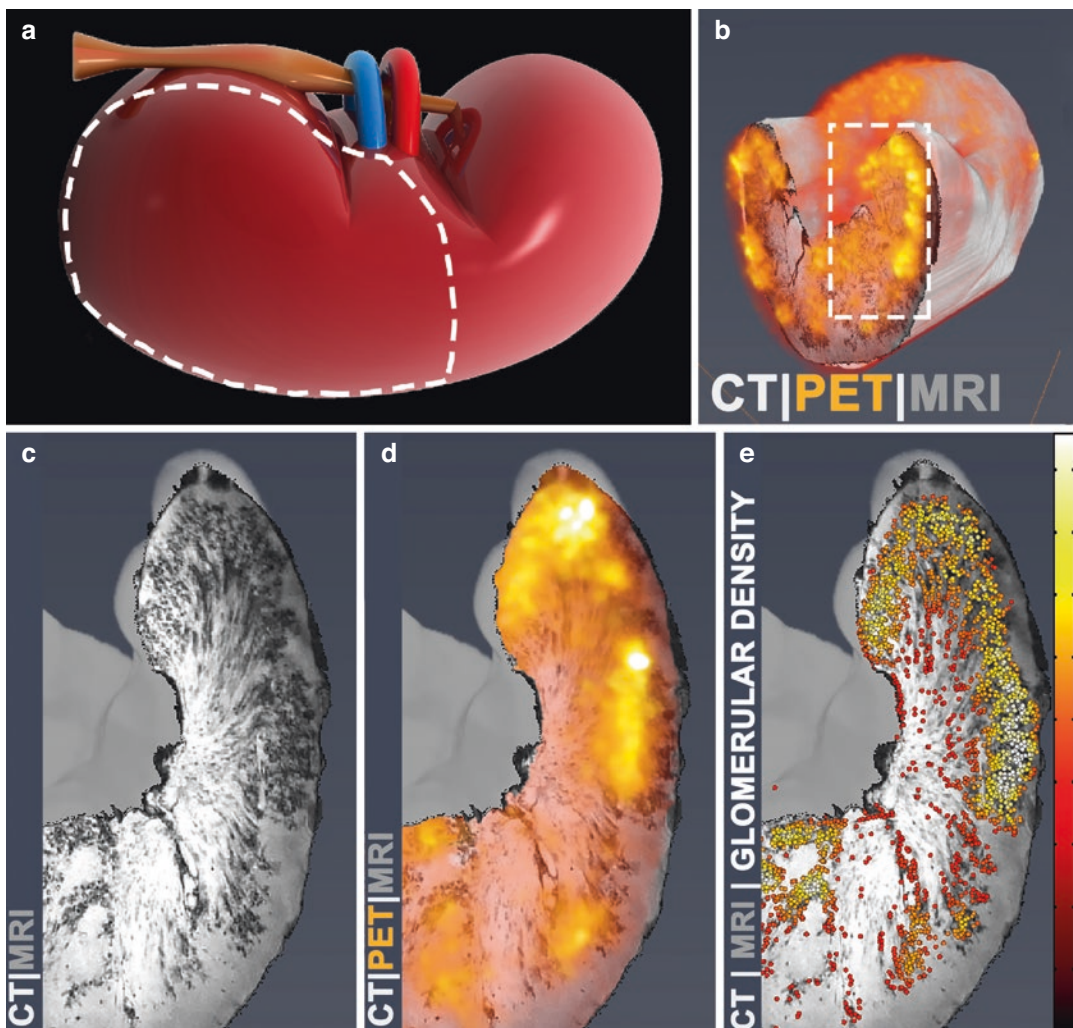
RadioCF-PET to measure nephron mass in a perfused human kidney. (a, b) A human kidney, rejected for transplantation and consented for research received RadioCF and imaged with: PET for RadioCF enhancement; x-ray-computed tomography (CT) for localization;
